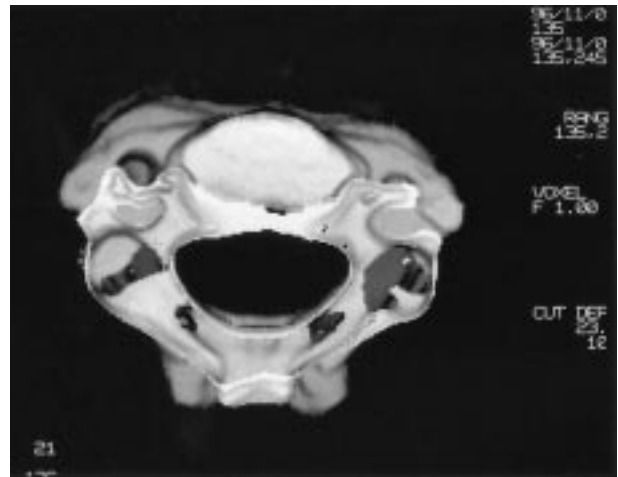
A cervical 3-dimensional computed tomography reconstruction showing a fracture in the anterior aspect of the right C3 transverse process bending posteriorly to narrow the vertebral foramen
